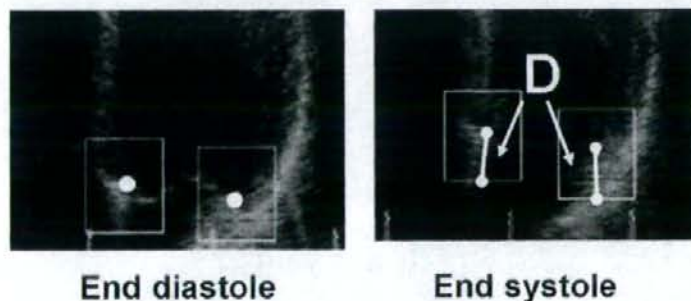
An example of automated distance measurements in apical four-chamber view of a normal healthy volunteer by AMAT. As the left picture, mitral annular points (white circles) are identified manually at the basal portion of inferoseptal wall and lateral wall in apical four-chamber view at end-diastole. As the right picture, the lower white circles selected as mitral annular points at end-diastole moves to the upper white circles that shows mitral annular points at end-systole. The distances between the lower point and the upper point at each side (distance D) are automatically measured.
